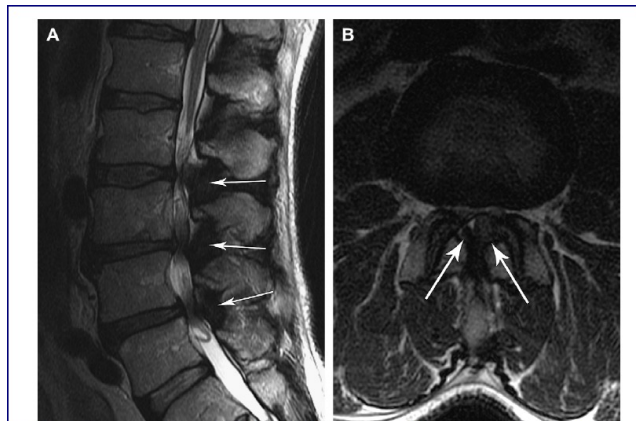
Facet joint osteoarthrosis and spinal stenosis. A 67-year-old man with low back pain and weakness in both legs exacerbated with walking. Sagittal (A) and axial (B) FSE T2-weighted MR images demonstrate multilevel loss of disc space height with resultant redundancy of the ligamentum flavum (arrows), causing severe spinal stenosis at each level.
